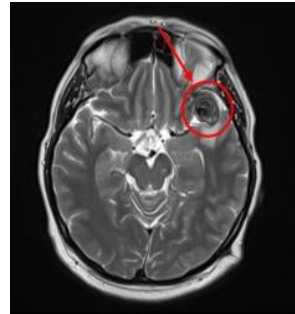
MRI T2 sequence
